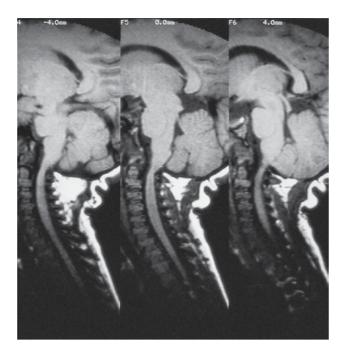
MRI of RF, a patient with MSD. A localized quite marked constriction of the anteroposterior diameter led to compression of the cord to about one-half normal size.
